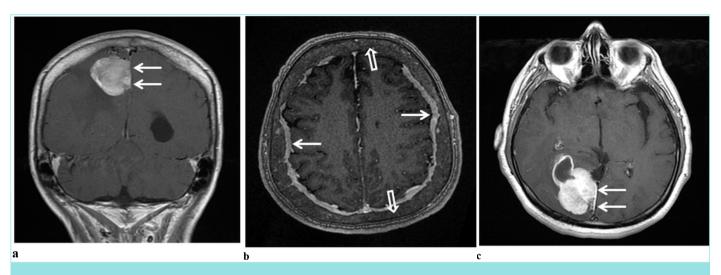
On contrast-enhanced T1-weighted magnetic resonance imaging, a) The dura-based mass reveals mildly heterogeneous and intense enhancement (arrows) direct dural involvement due to thyroid follicular cancer. b) Bone and dural involvement due to acute myeloid leukemia contrast-enhancing and thickening, nodular and linear in places, of mixed pattern dural involvement are shown. c) Pleomorphic xhantoastrocytoma which caused focal metastasis (white arrows) from parenchyma to falcine dura is shown.
